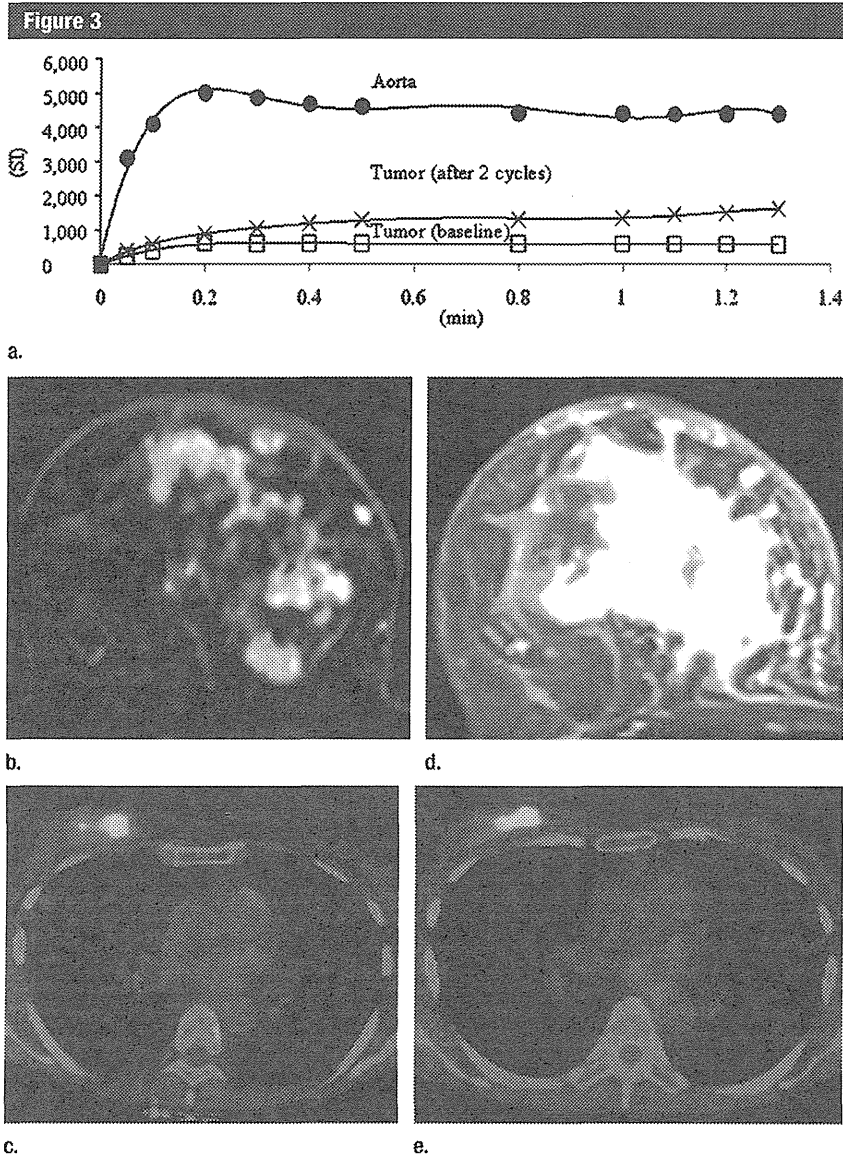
Changes after NAC in a 52-year-old woman with invasive ductal carcinoma of the right breast showing no pCR. (a) Time-intensity curves. SI = signal intensity. Axial (b, d) DCE MR and (c, e) ^{18}F -FDG PET/CT images (b, c) at baseline and (d, e) after two cycles of NAC. Significant increase in the mean values of all parameters from baseline was observed after two cycles of NAC: K^{trans} , from 1.6 to 4.8 1/min; κ_{ep} , from 1.1 to 3.4 1/min; AUC_{90} , from 32.5 to 68.7 mmol/L-sec; SUV_{max} , from 14.7 to 16.5 g/mL; SUL_{peak} , from 7.8 to 9.7 g/mL; and TLG, from 114.0 to 256.2 $\text{g} \cdot 10^{-3}$. The status after two cycles of NAC was progressive disease according to RECIST 1.1, progressive metabolic disease according to EORTC, and progressive metabolic disease according to PERCIST 1.0.
